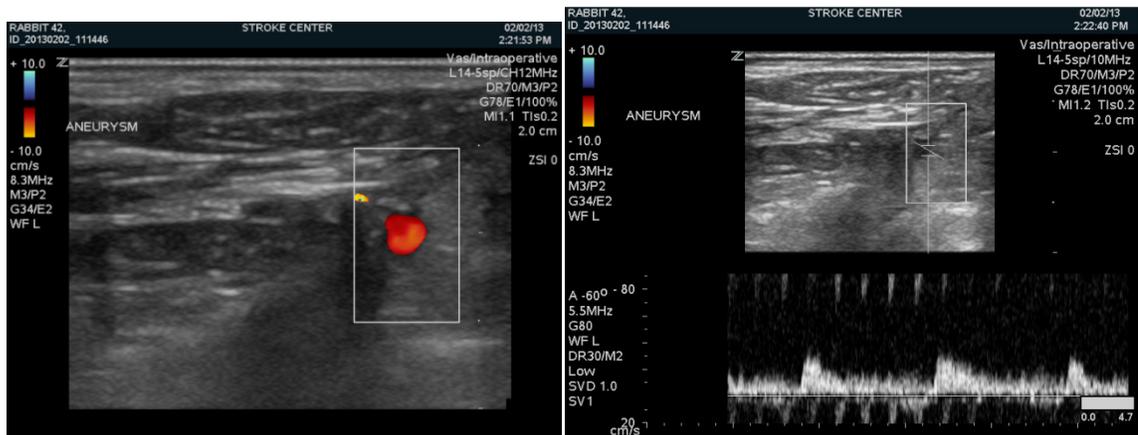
Left. The Color Doppler mode is used to visualize flow inside the aneurysm. Right. The Pulse Wave Doppler mode is used to measure blood flow inside the aneurysm.
